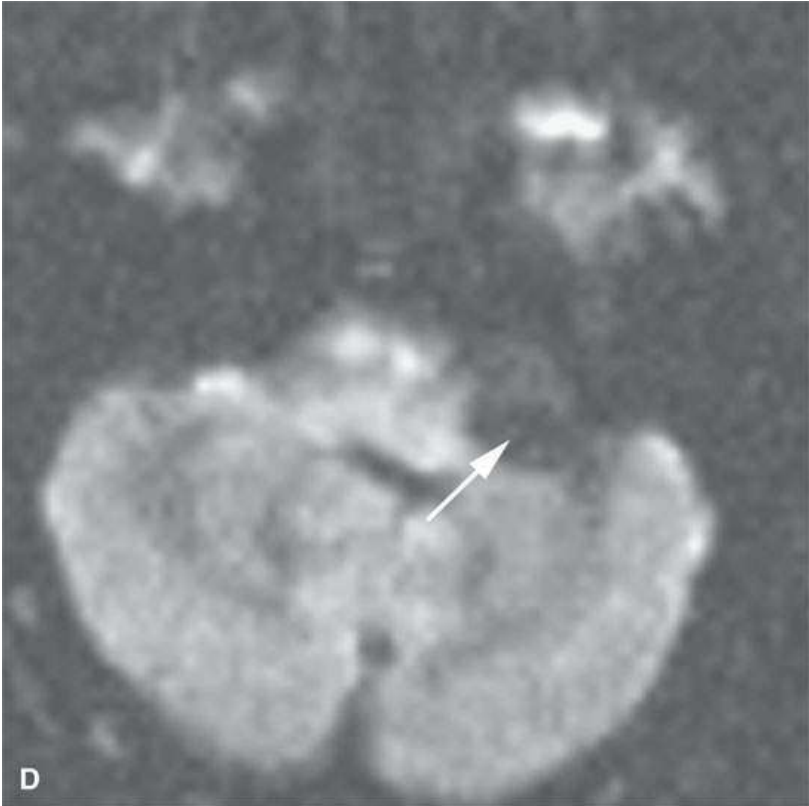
Magnetic resonance imaging of a patient with a cerebellopontine angle (CPA) arachnoid cyst. A: T1-weighted images shows the cyst (*arrow*) displacing the nerves and remodeling of the petrous bone. B: T2-weighted image shows the same findings as in (A) and that the relatively static fluid in the cyst is brighter than the cerebrospinal fluid (CSF) in the contralateral CPA (*arrowhead*). C: Fluid attenuation inversion recovery (FLAIR) image is relatively motion sensitive, and the brighter signal in the cyst (*arrow*) is due to CSF motion. D, E: These images show no evidence of restricted diffusion in the cyst (*arrows*).
